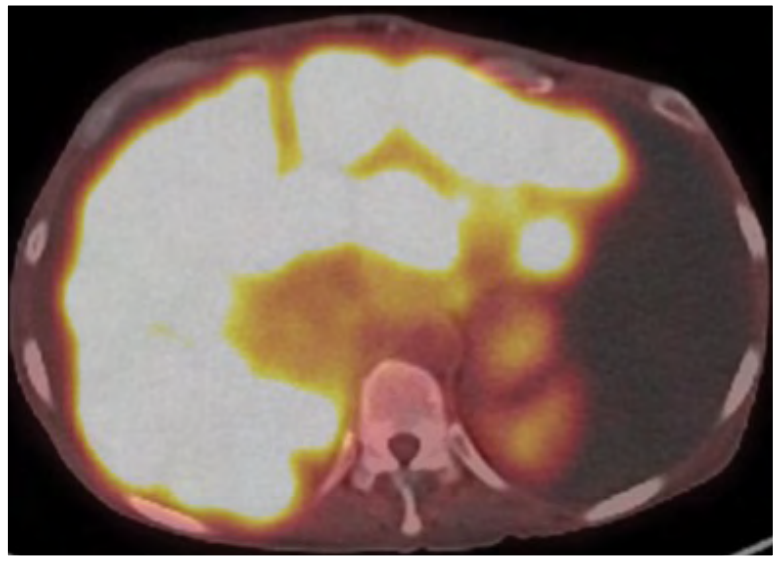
Ga-68 dotatate PET/CT scan demonstrating innumerable FDG-avid masses of the liver, consistent with Mrs. R's known history of metastatic neuroendocrine malignancy.
